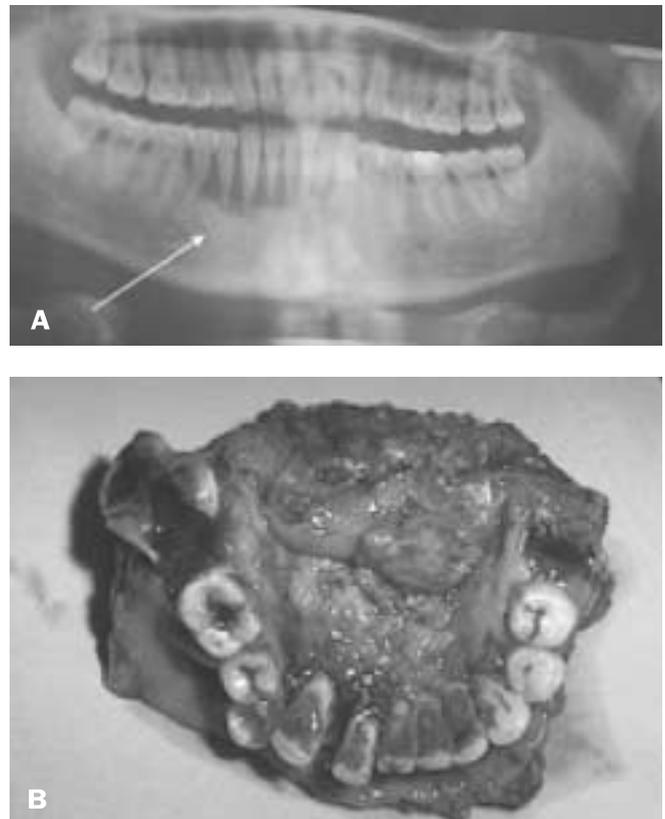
[A] Panoramic X-ray of the tumor. [B] The resected section.
